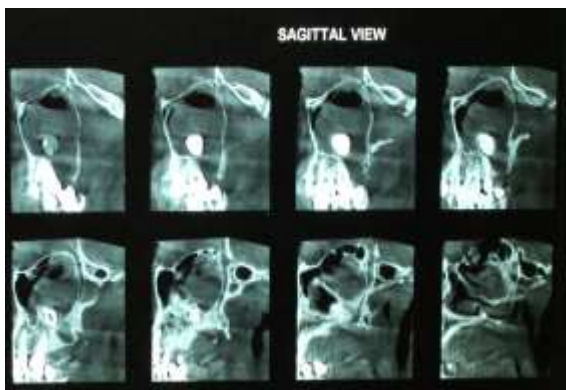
Sagittal view CBCT
